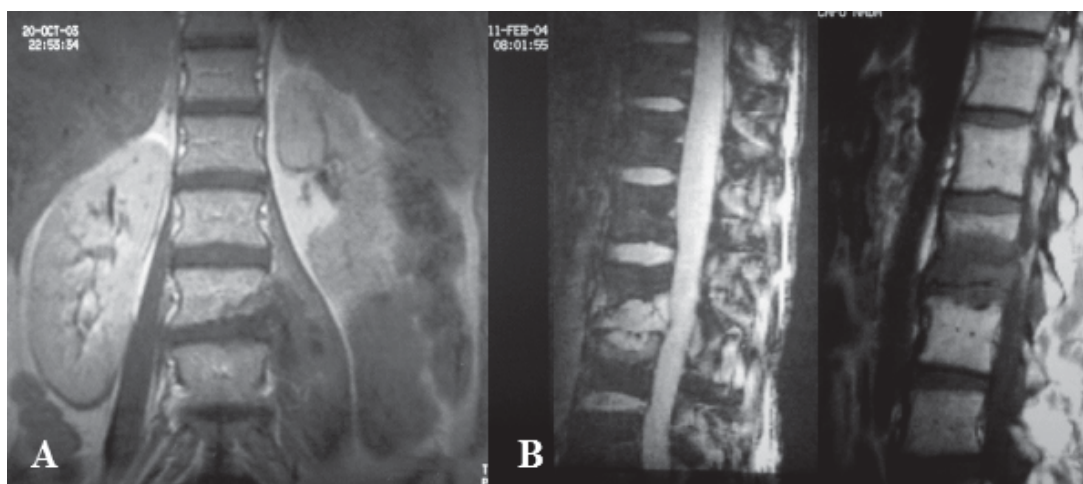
Magnetic resonance imaging of the lumbar spine in the presented patient with disseminated *R. equi* infection: progressive spondylodiscitis L2/L3 and psoas abscess of the left side.
